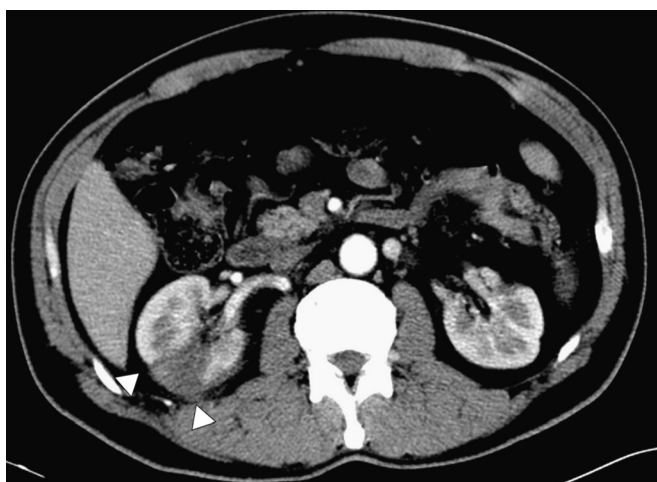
Contrast-enhanced abdominal computed tomography imaging. Wedge-shaped perfusion defect is shown in the right kidney (arrowheads).
